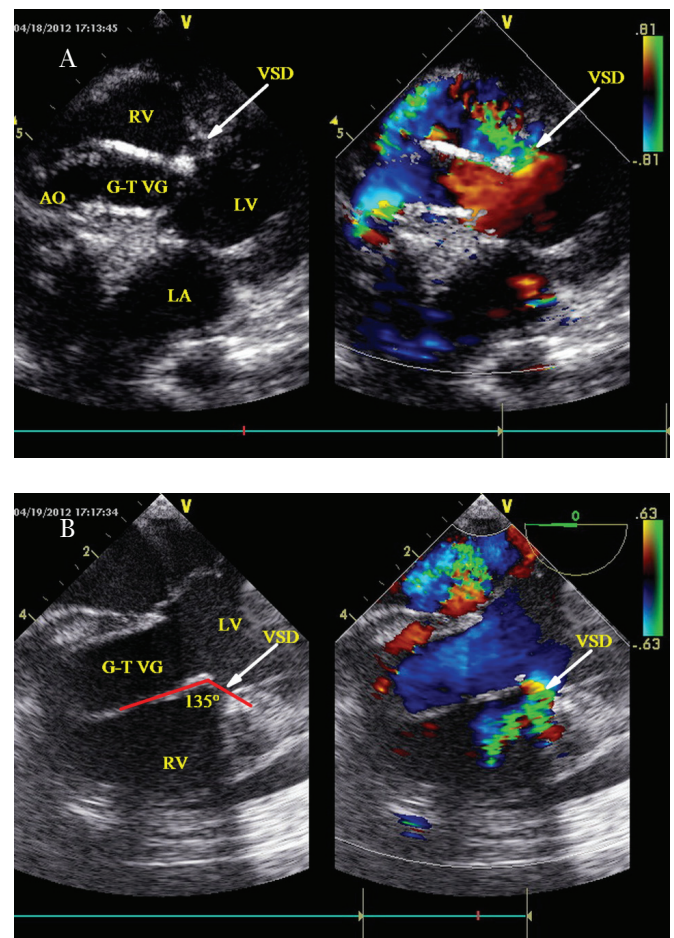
A, Left: Transthoracic echocardiography showing R-VSD after surgical correction of double-outlet right ventricle (arrow). Right: Transthoracic echocardiography showing a significant left-to-right shunt of R-VSD (arrow). B, Left: TEE showing an angle of  $135^\circ$  between the G-T VG and the R-VSD. Right: TEE showing a significant left-to-right shunt of R-VSD (arrow). TEE, transesophageal echocardiography; R-VSD, residual ventricular septal defect; LV, left ventricle; RV, right ventricle; LA, left atrium; G-T VG, Gore-Tex vascular graft; AO, aorta.
